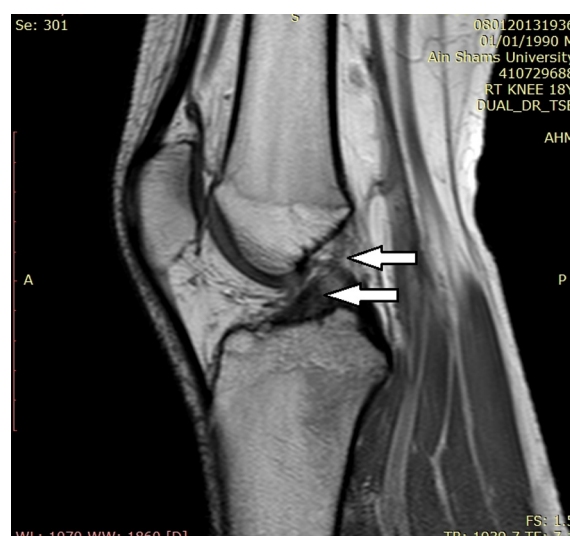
Sagittal T2W knee MR image, AHMM shows linear signal alteration disrupting the inferior articular surface suggesting post traumatic tear (arrow head). PHMM shows irregular signal abnormality disrupting superior, inferior and capsular surfaces (arrow).
